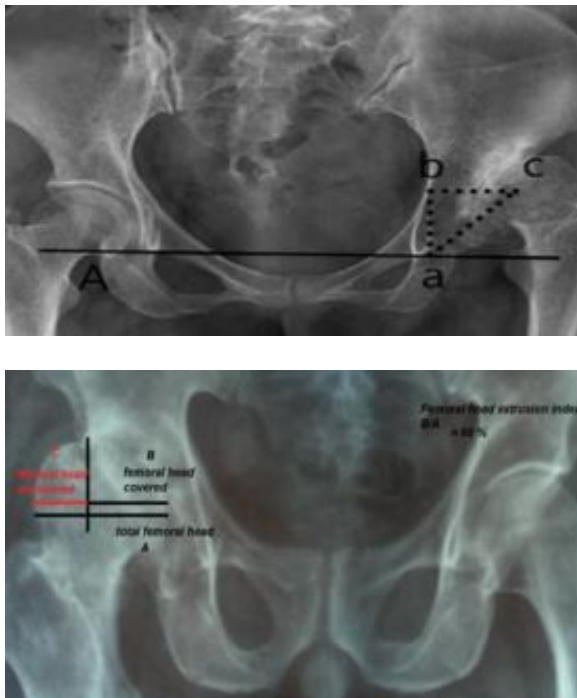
Ranawat's triangle on an anteroposterior pelvic radiograph. Line A is the inter-teardrop line. Point (a) is located 5 mm to the same side tear drop. Triangle abc, the length of ab and bc is equal to 20% of the pelvic height. Femoral head extrusion index in patient with acetabular dysplasia.
